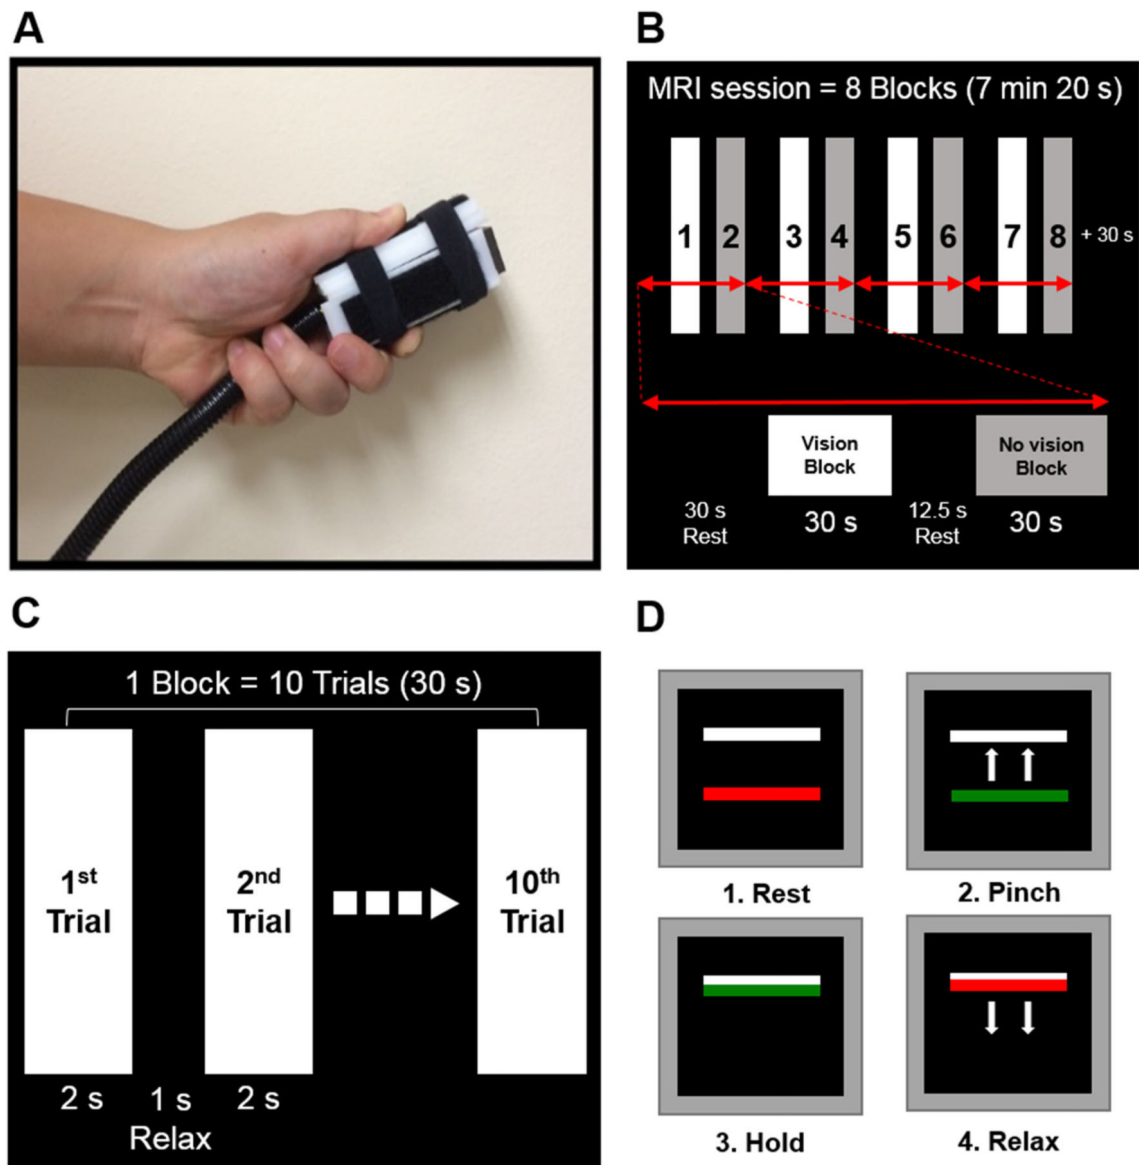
Pinch grip force control task in MRI scanner. Grip force apparatus (a). MRI session with eight *blocks* (b). *Block* design including 10 trials (c). Visually guided force control task (d)
